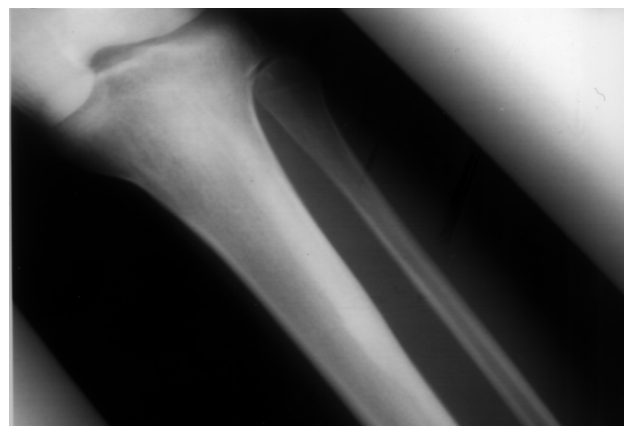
X-ray of knee showing a typical candle wax appearance
